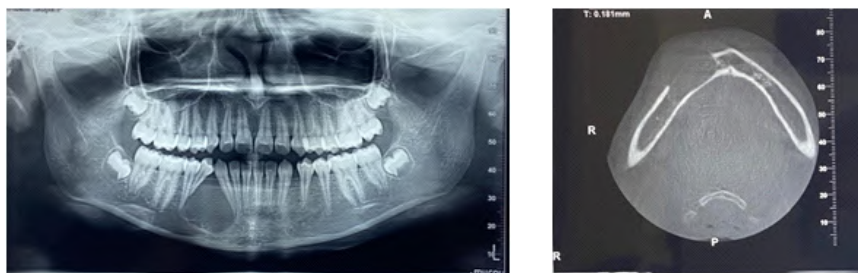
OPG demonstrating well-defined unilocular radiolucent lesion in the right mandible and CBCT demonstrating buccal cortical plate perforation
